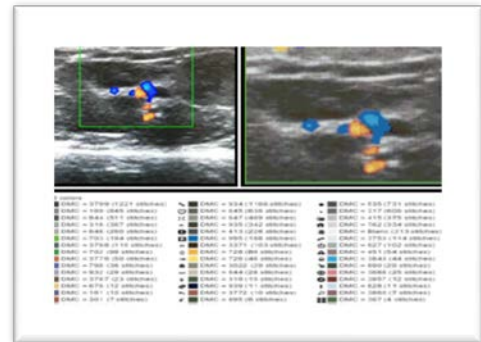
Colour Doppler imaging show increased vascularity at 7 day duration in chia seeds oil treated group.
